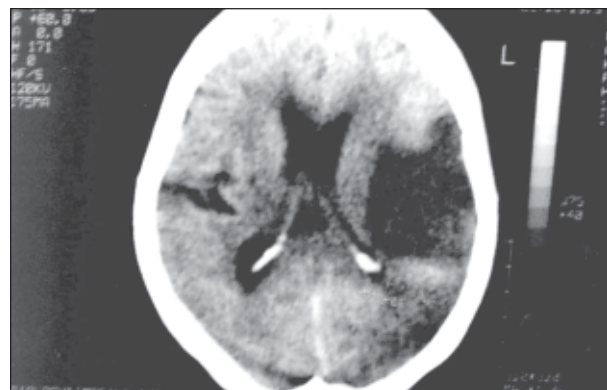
CT-Scan of brain showing large extensive infarct involving left parietal region extending from cortex to subcortical white matter at left MCA territory.
